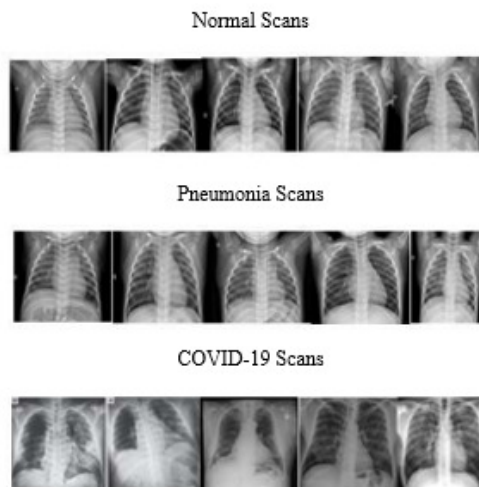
Scans of Normal, Pneumonia and COVID-19 Infected Chest- X-Rays.
